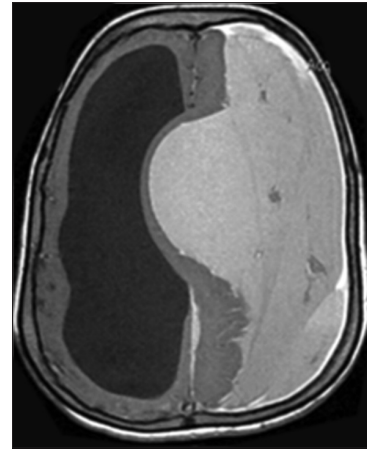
Preoperative T1 weighted MRI showing giant chronic subdural hematoma
